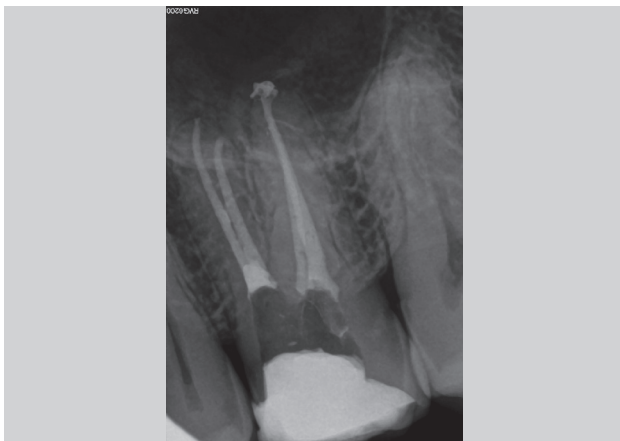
Postobturation periapical radiograph of a left first maxillary molar that presented with separate MB1 and MB2 canal systems. Note that the MB2 was shorter compared to the MB1 canal system.
